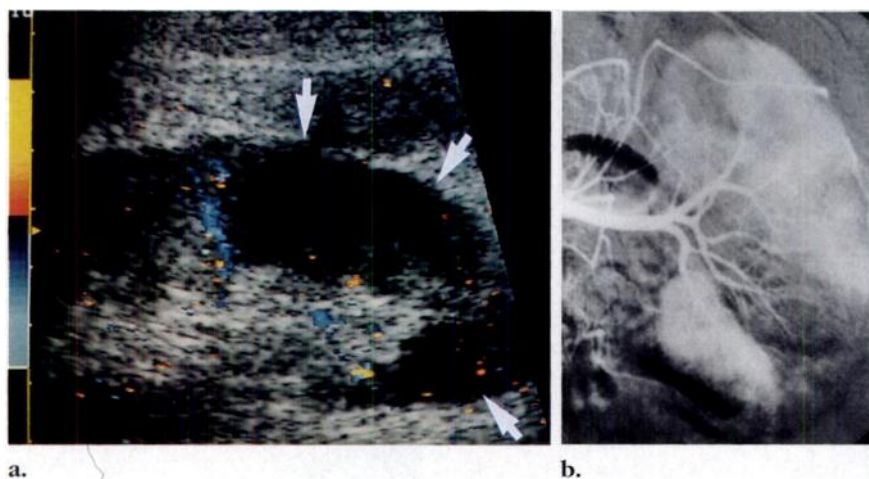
Large cortical infarcts. (a) Color Doppler sonogram shows hypoechoic areas without flow (arrows). (b) Selective angiogram of the left kidney demonstrates multiple cortical defects comparable with those of the opposite side (not shown).
